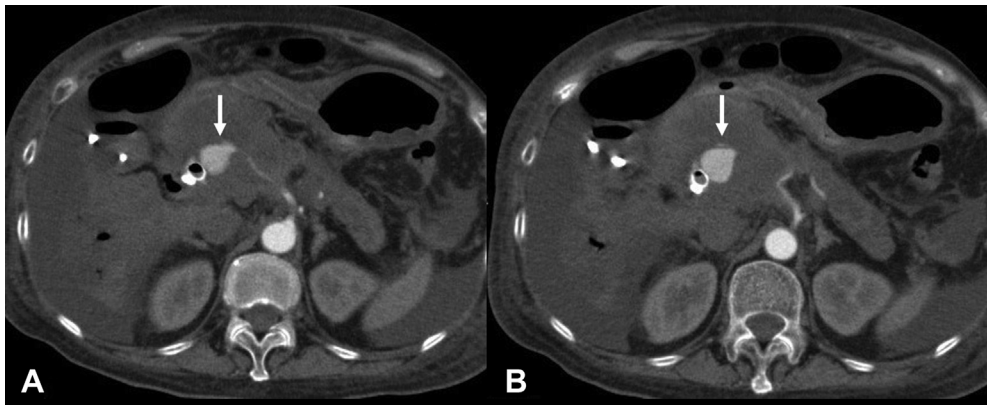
A, The CT shows a 2-cm pseudoaneurysm (*arrow*) arising from a branch of gastroduodenal or proper hepatic arteries and located in a tumor of the pancreas that was not evident 2 weeks earlier. B, The pseudoaneurysm was just adjacent to the biliary self-expandable metallic stent.
